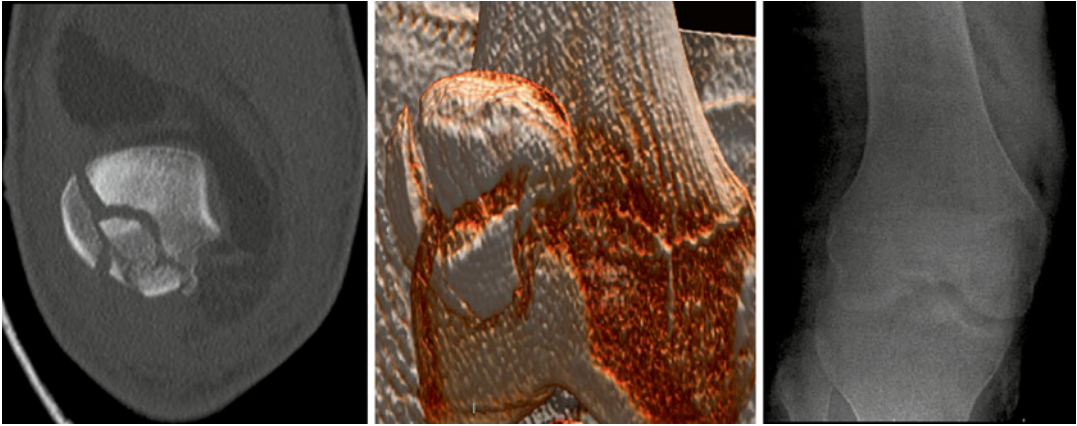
Plain radiograph, coronal CT and 3D reconstruction of a stellate [comminuted] fracture of the patella
